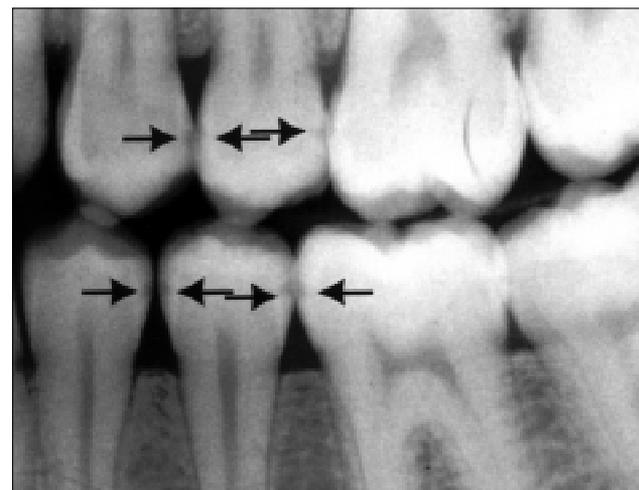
Case 2: 15 year, 8-month-old male. Left bitewing radiograph.
